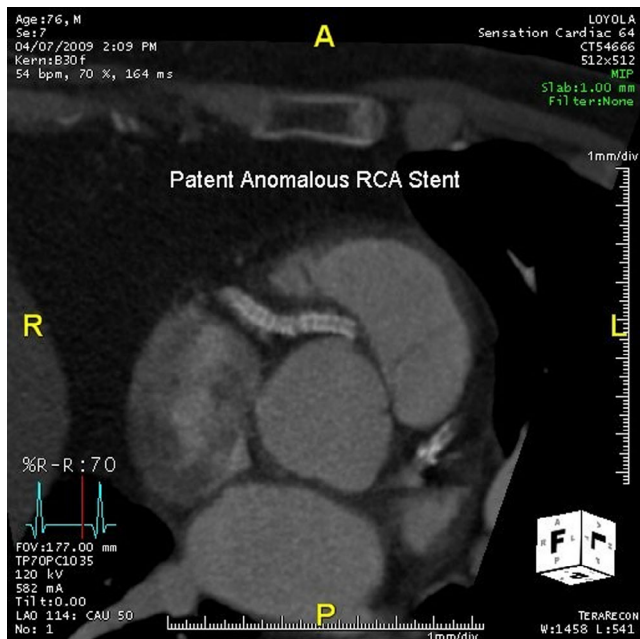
Cardiac CTA, done 11 months post-PCI, showing a patent stent in the proximal segment of an anomalous RCA. PCI, percutaneous coronary intervention; RCA, right coronary artery [Color figure can be viewed at wileyonlinelibrary.com]
